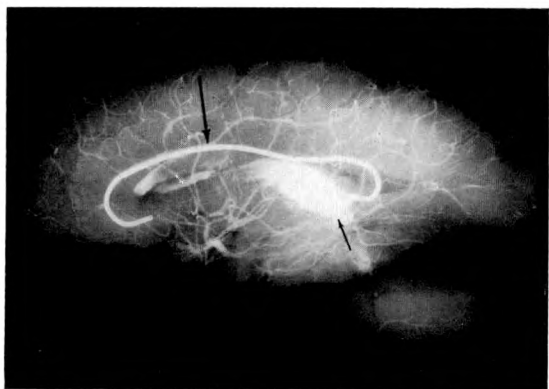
Roentgenogram of a sagittal section through the brain. The sulcus of the corpus callosum is outlined with solder (large arrow), and the cisterna veli interpositi and a portion of the quadrigeminal cistern (small arrow) are filled with barium paste.
